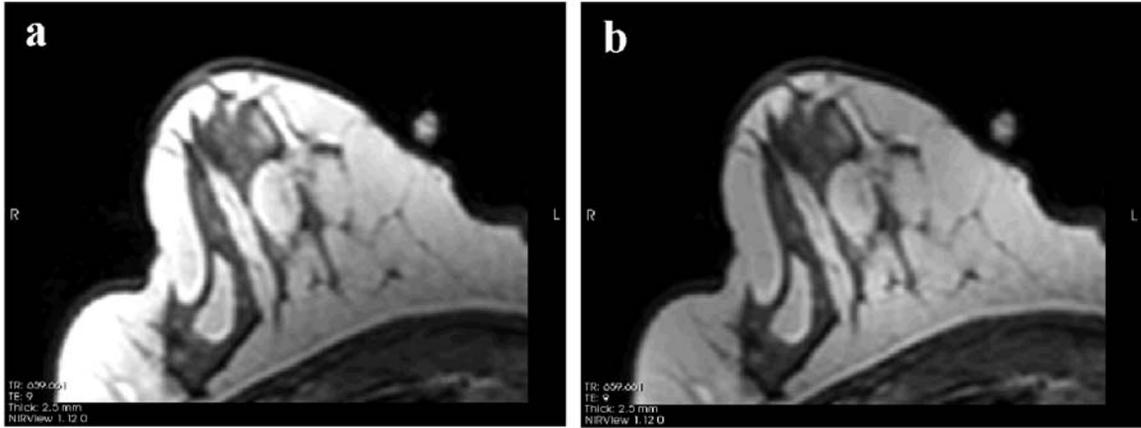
(a) Original MRI axial slice of the breast with a low frequency gradient visible, the bright regions on the left fading into lower values on the right, (b) same axial slice of the breast with MR bias field correction applied to remove the low frequency gradient.
